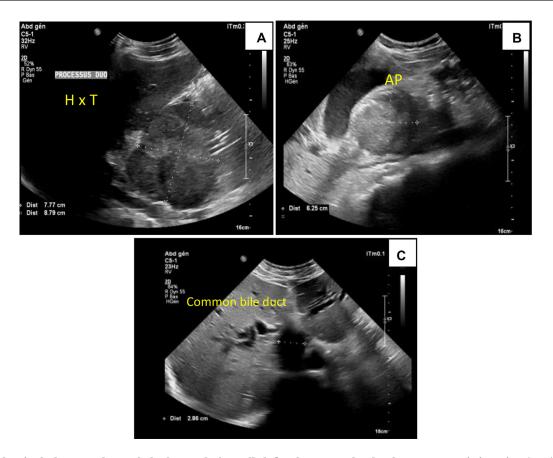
Abdominal ultrasound revealed a hypoechoic, well-defined mass at the duodeno-pancreatic junction (A, B), associated with dilatation of the intrahepatic and extrahepatic bile ducts (C).
